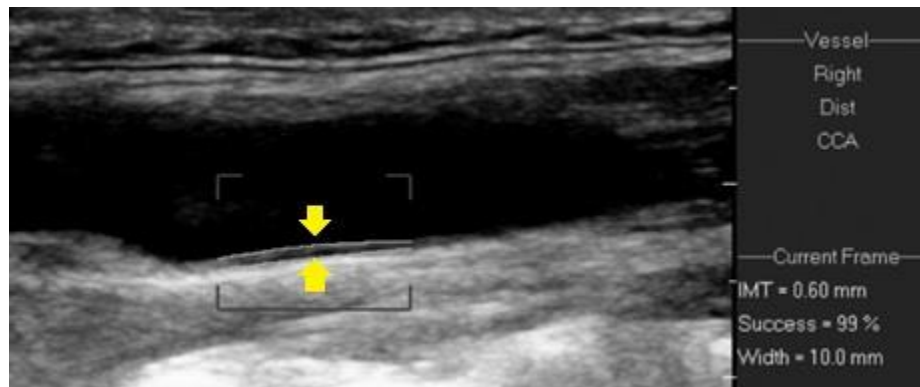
Example of intima-media thickness measurement using ultrasound.
